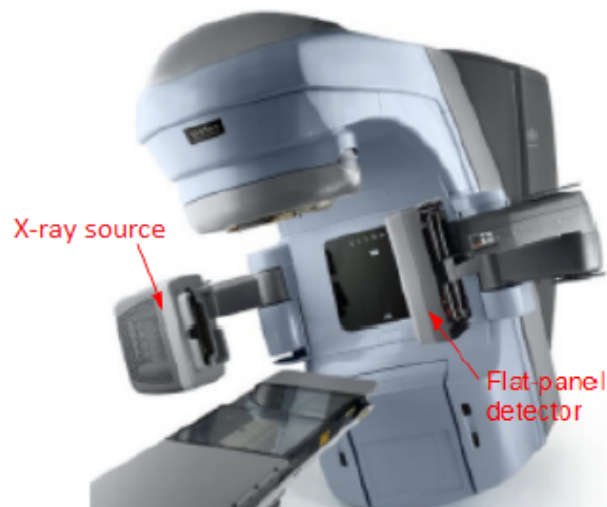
Acquisition system with integrated the linear accelerator in the treatment room. There are visible the Flat-panel detector and the X-ray source.
